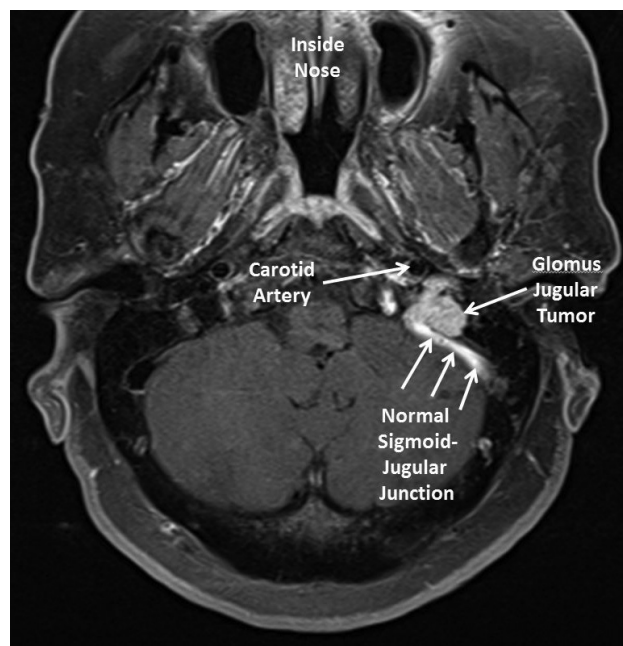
Axial T1 post-gadolinium (post-contrast) MRI showing an enhancing (white) mass of the jugular foramen that is distinct from the sigmoid–jugular junction (where the sigmoid sinus drains into the jugular bulb).
